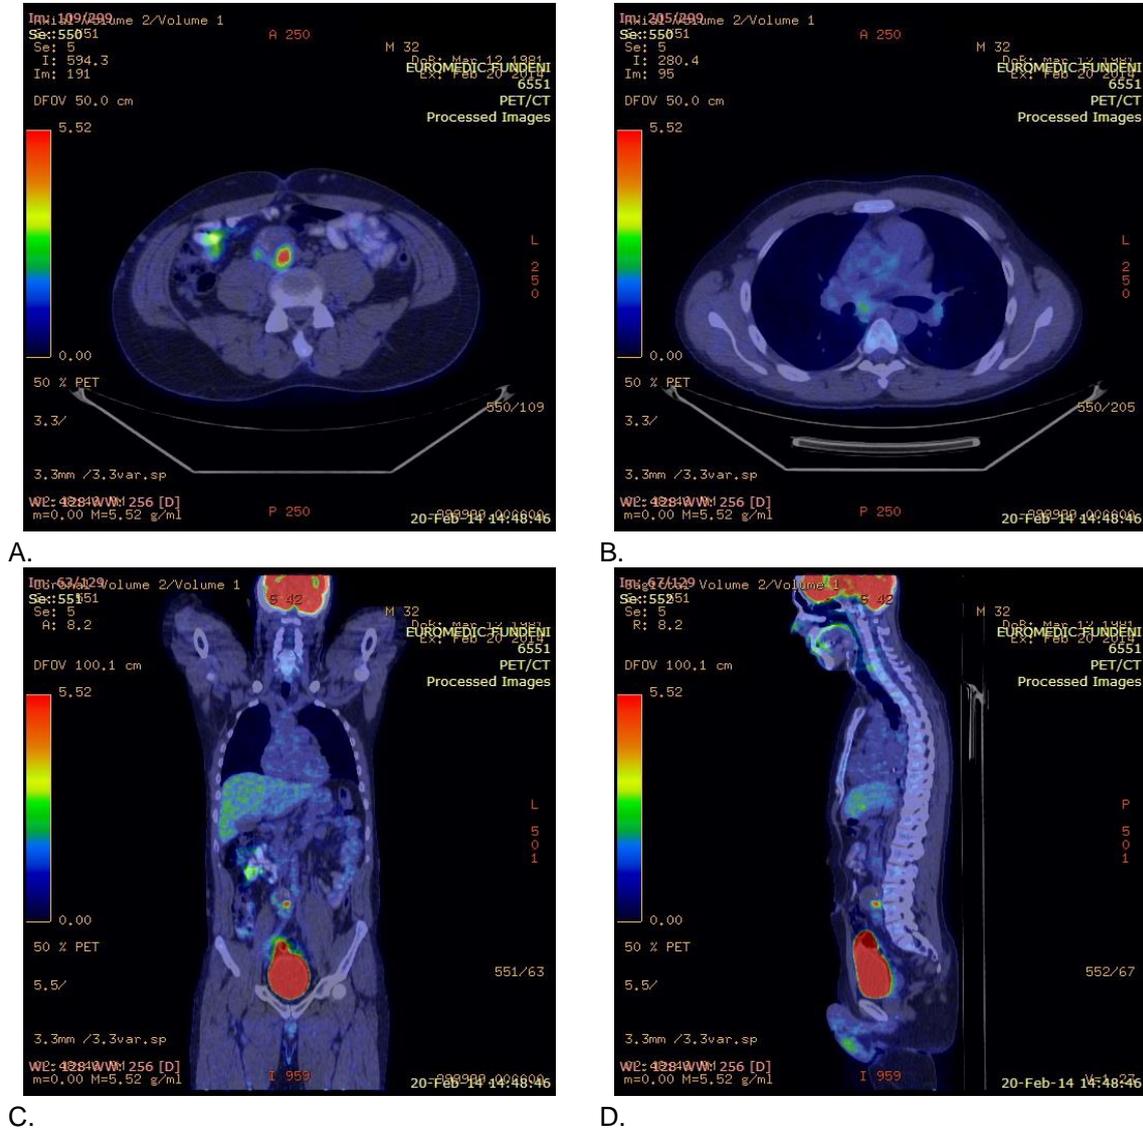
Images from the ¹⁸F-DG PET-CT scan performed after salvage chemotherapy: A. Axial view, residual precaval adenopathy; B. Axial view, complete response of lung metastases; C. Coronal view, residual precaval adenopathy and normal liver; D. Sagittal view, residual precaval adenopathy.
